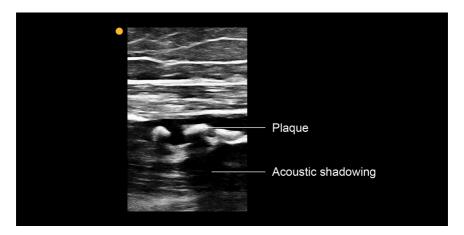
On a duplex Doppler ultrasound, calcific plaque will appear echogenic (e.g., bright) and will be accompanied by acoustic shadowing (e.g., black shadow).
